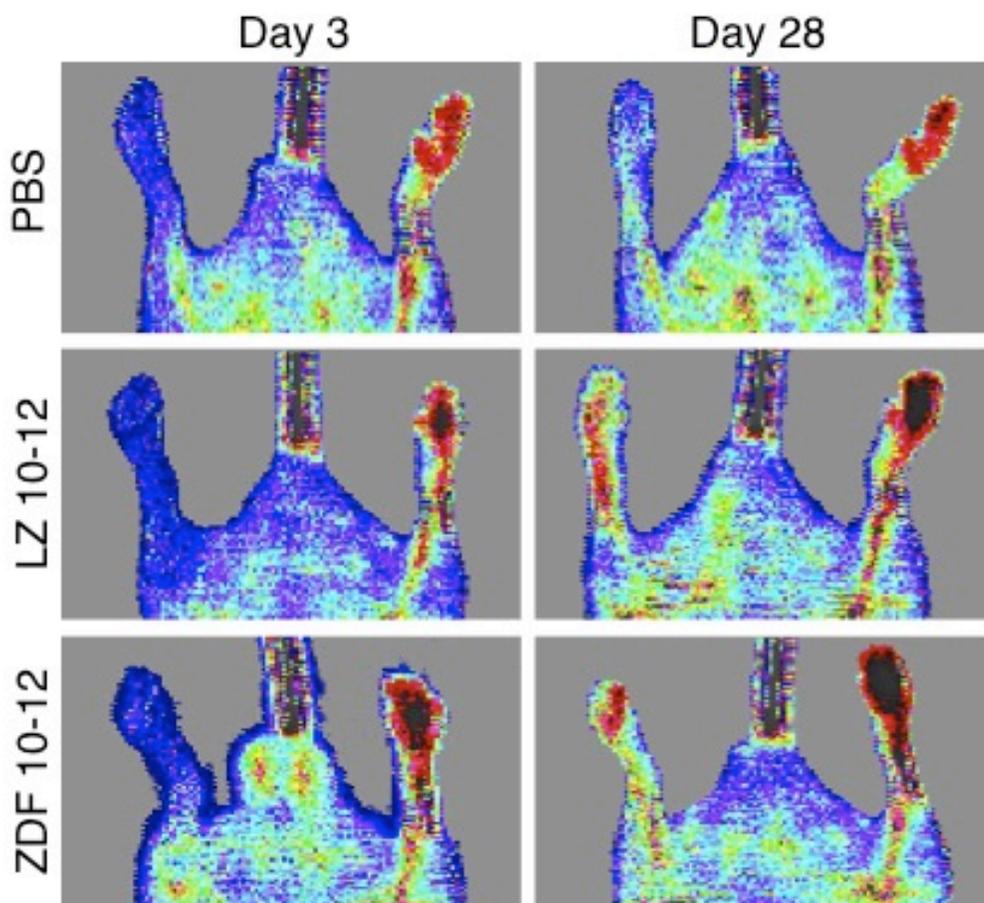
Representative Laser Doppler Perfusion Images
